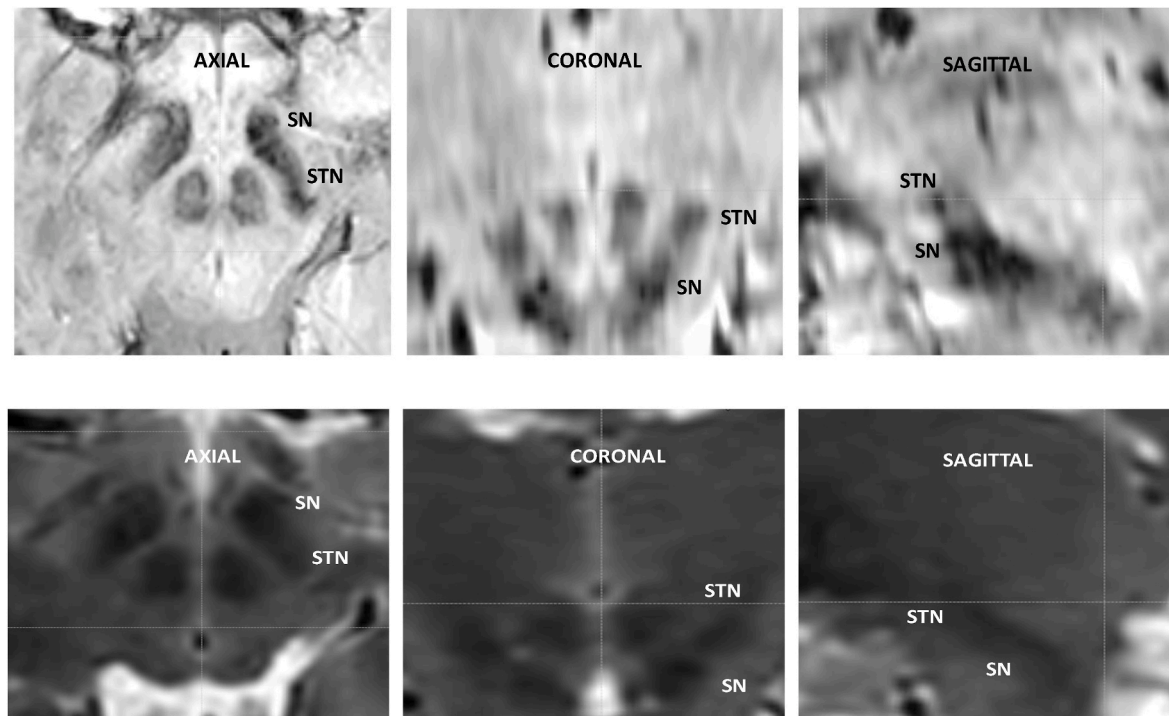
Preoperative stereotactic planning of STN targeting on MRI 3T sequences.
